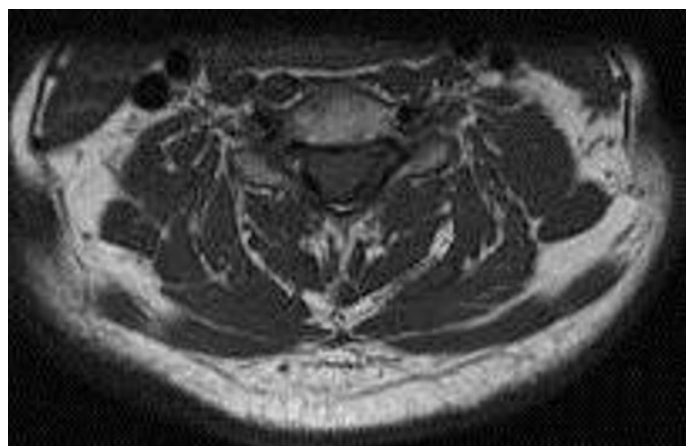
Axial T1-weighted MRI showing a hyperintense lesion in the T2 vertebral body, characterizing the ivory vertebra.
